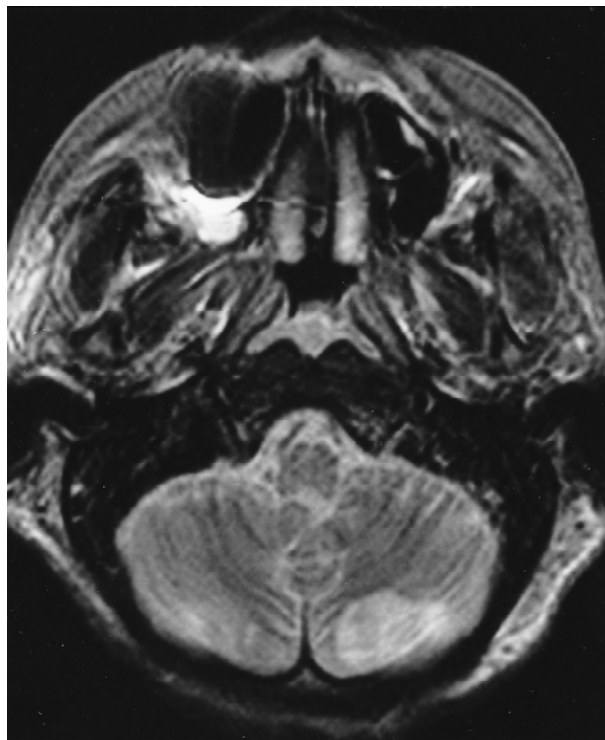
T2-weighted magnetic resonance image of the brain showing areas of high signal intensity in both cerebellar hemispheres
